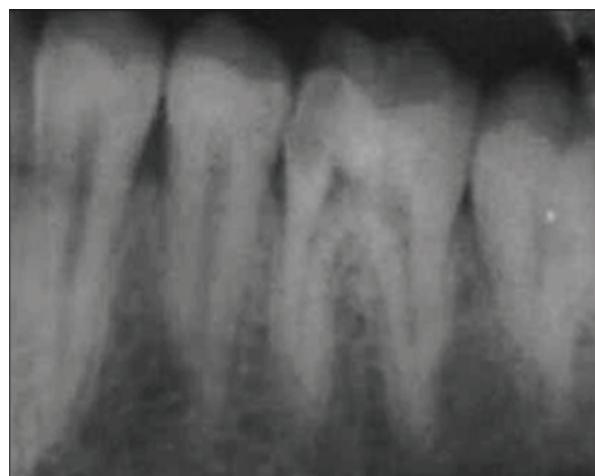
Pre-operative radiographic
